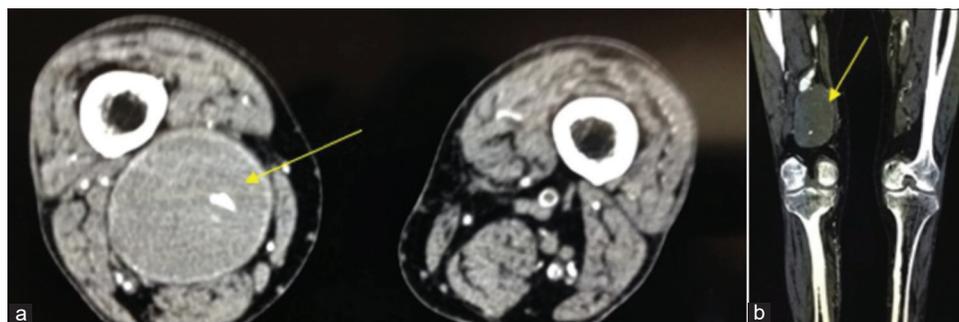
Computed tomography axial (a) and coronal reformat (b) demonstrating a right popliteal aneurysm (yellow arrow) which is completely occluded with thrombus.
